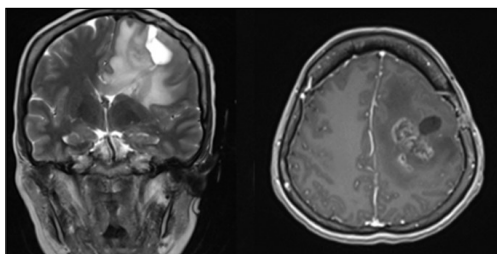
A coronal T2-weighted image showing left frontal cystic encephalomalacia with local mass effect, and residual tumour plus post-radiation necrosis seen on axial T1-weighted image with gadolinium
